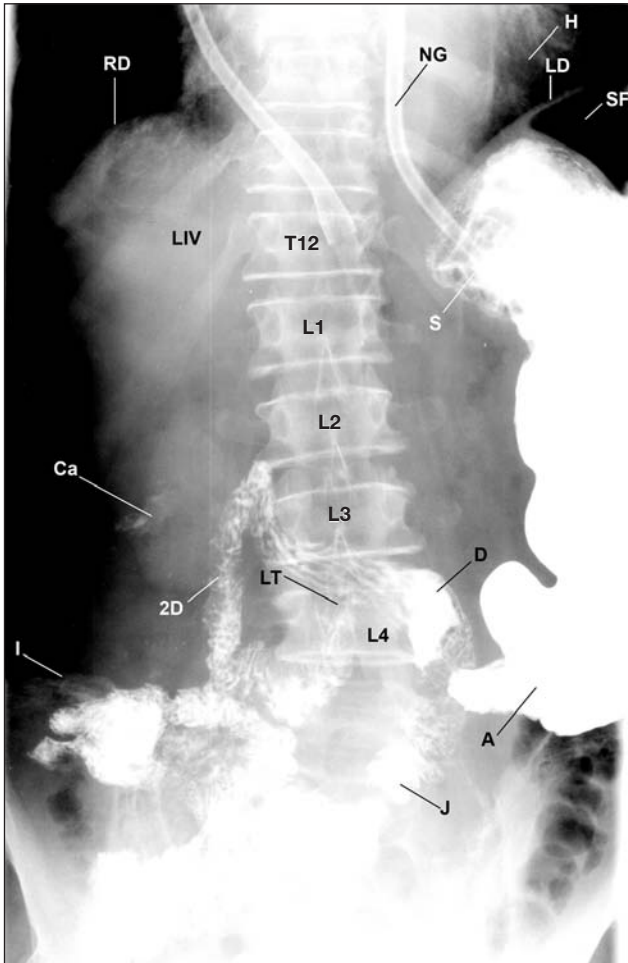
This is an anteroposterior radiograph of the abdomen after an upper gastrointestinal series. The barium was introduced under fluoroscopic control through a nasogastric tube (NG), with its tip directed into the stomach (S). Observe the left lateral displacement of the barium-filled duodenum (D) and antrum (A) of the stomach, the inferior displacement of the ligament of Treitz (LT), the jejunum (J), and the calcifications (Ca) compared with Figure 1 (page 16). 2D = second (descending) part of the duodenum; H = heart; I = iliac bone; LIV = liver; LD and RD = left and right hemidiaphragm; T12 = thoracic vertebra; L1-L4 = lumbar vertebrae, SF = splenic flexure.
